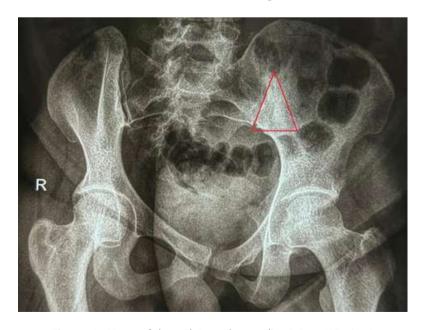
X-ray of the pelvis and sacroiliac joints (AP view)
